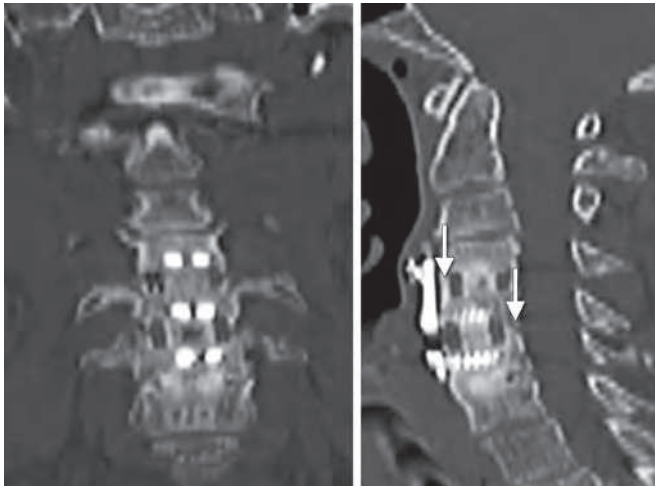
Computed tomography scan demonstrating bridging bone not only within the graft, but also outside (arrows) the confines of the graft.
